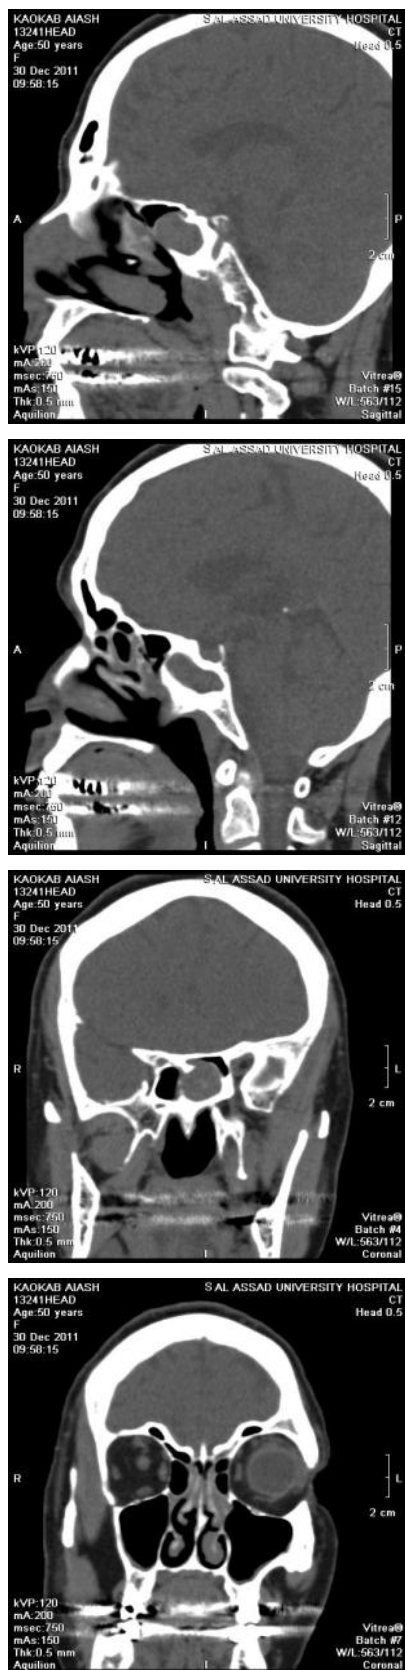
CT scan of the patient indicating pathology in the left sphenoid sinus.
